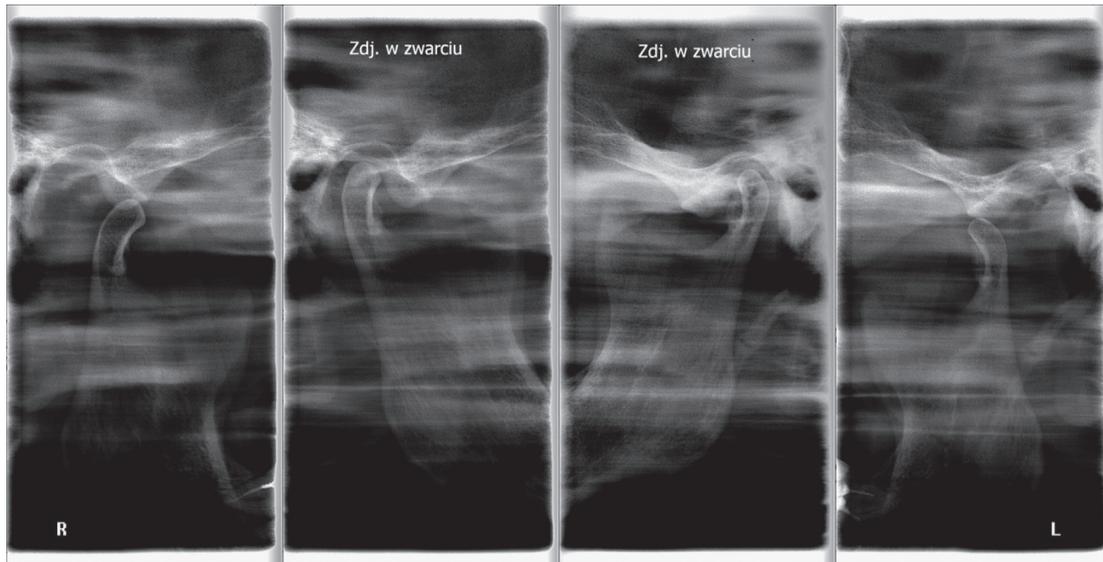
The radiographs of a nonconcentric condylar position: deficient vertical dimension (condylar position in occlusion—internal scans) and a muscle contracture in the right TMJ.
